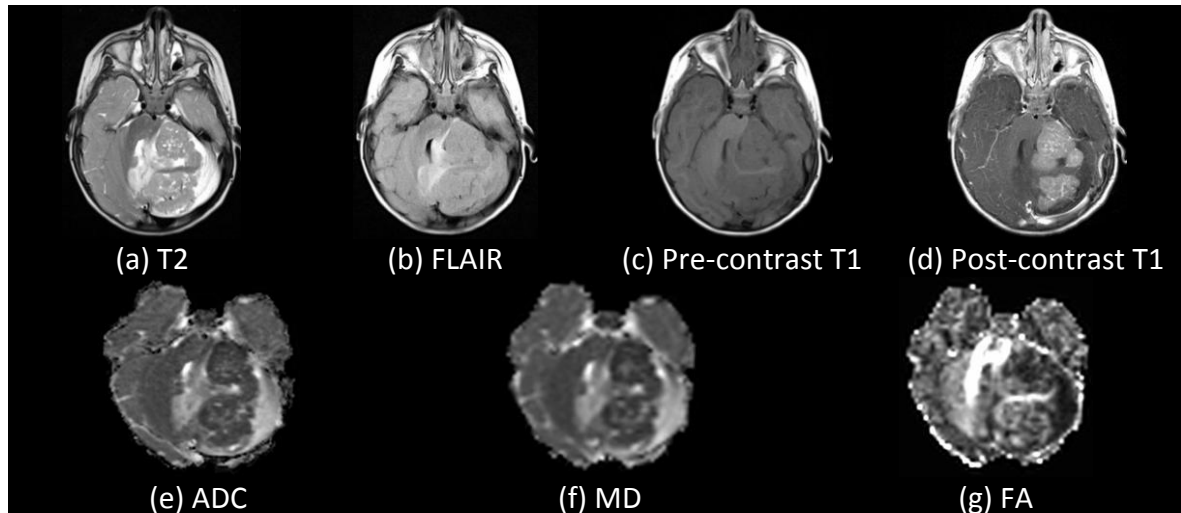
Imaging characteristics of a desmoplastic medulloblastoma based on T2, FLAIR, pre-contrast T1, post-contrast T1, ADC, MD and FA (case MB862).
